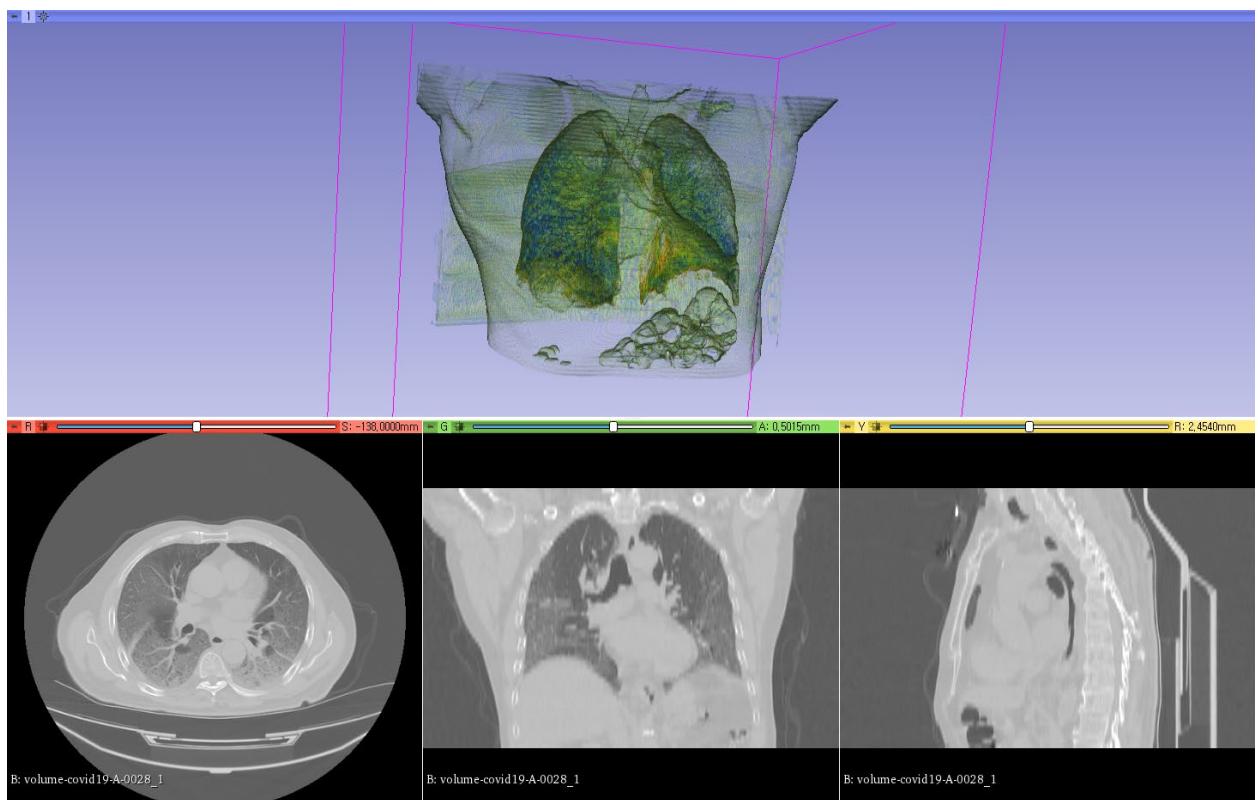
COVID Patient 28 Lung CT Scan: 2D and 3D Rendering Using 3D Slicer
